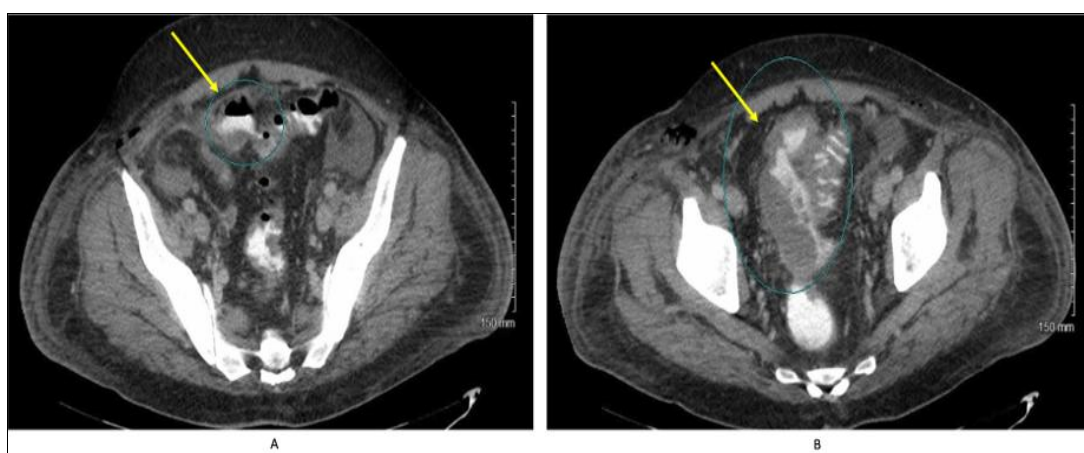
(A-B)(CT A/P axial image; cranial to caudal): Abscess with enteric communication. Tubular fluid collection extends along the anterior midline pelvis, then courses posteriorly into the prerectal space. This is likely intimate with a diseased loop of sigmoid colon. Findings most consistent with diverticular abscess.
